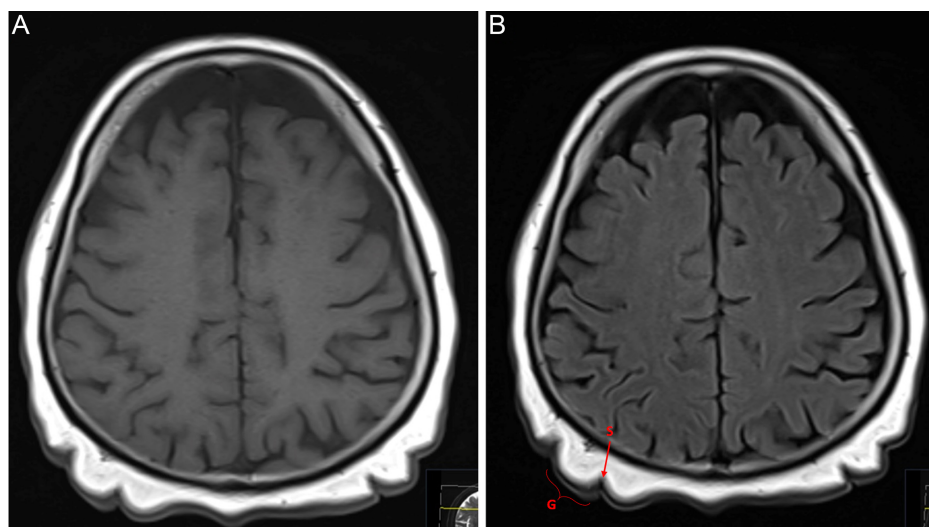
T1- and T2-weighted axial magnetic resonance images demonstrate cutis verticis gyrata on the scalp without any cerebral abnormalities. G, gyriform structure; S, sulcal morphology.
